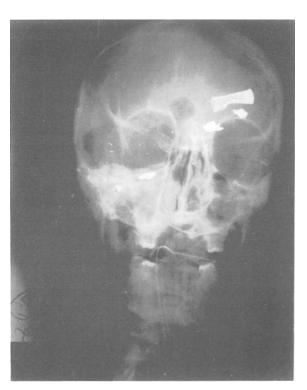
Premortem anteroposterior skull radiograph depicting location of projectile fragments and intracranial casing.
